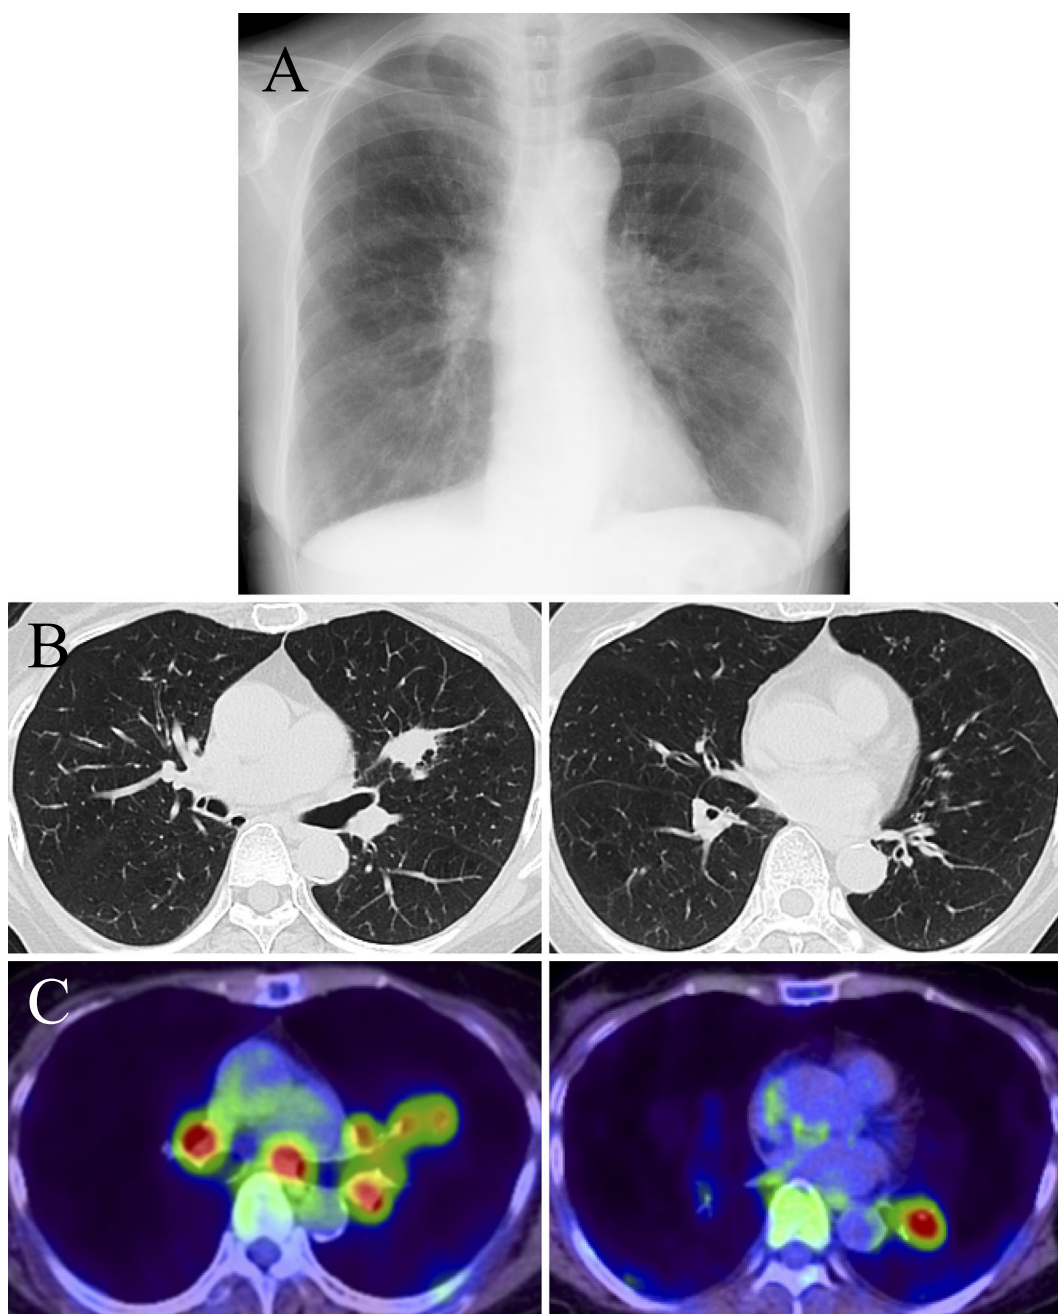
A: Chest X-ray taken on admission to our hospital shows bilateral hilar lymphadenopathy and a nodular lesion (2.5 cm in diameter) adjacent to the left hilum. B: Chest CT image. A nodular lesion (left S3) (left), highly thickened bronchial walls (right) and emphysematous changes are seen. C: FDG-PET image, corresponding to the CT image in (B). A strong uptake is observed in the lung nodule and hilar and mediastinal lymph nodes (left) as well as in the highly thickened bronchial wall (right).
